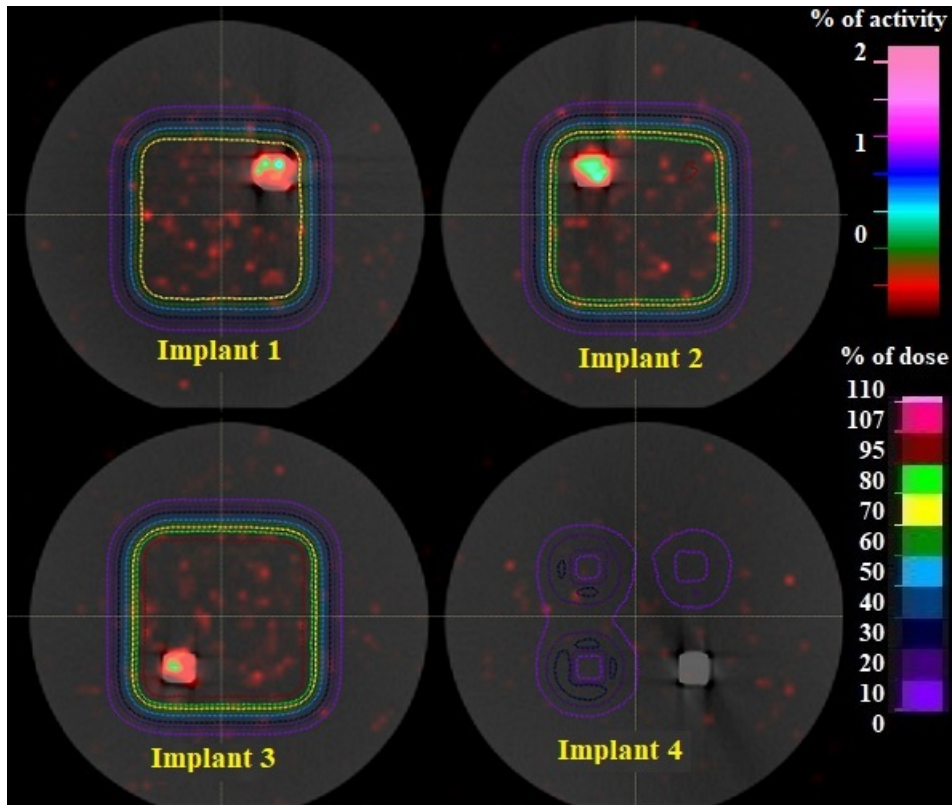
PET activity (color wash) of the first 30 min of the fourth hour matched with planned dose distribution (dashed lines) transferred from the planning CT on the CT for the PET reconstruction by a rigid image registration. The activities are comparably low due to the high activity from the ^{22}Na source in the PET image. The implants are sorted from the top left (Implant 1) to the bottom right (Implant 4).
